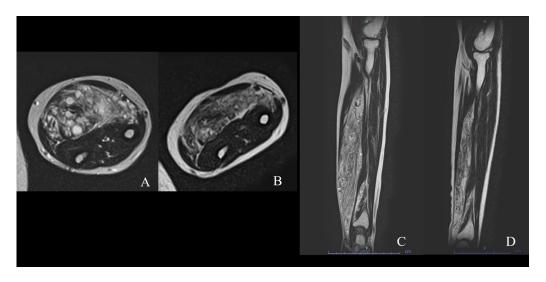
MRI imaging prior (A, C) and 3 months (B, D) after Sirolimus therapy. (A, B) Axial cut; (C, D) Sagittal cuts, showing significant decrease in the are of the lesion.
